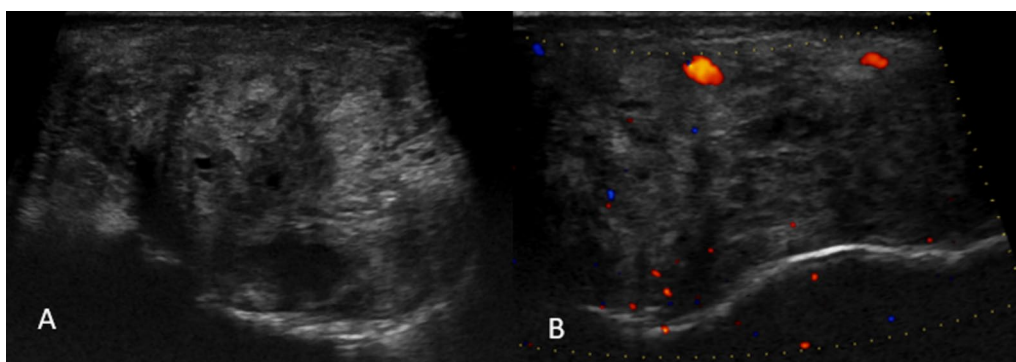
Linear USG (A) and color Doppler (B) image shows heterogeneously appearing soft tissue mass with few anechoic areas within showing minimal vascularity on color Doppler
